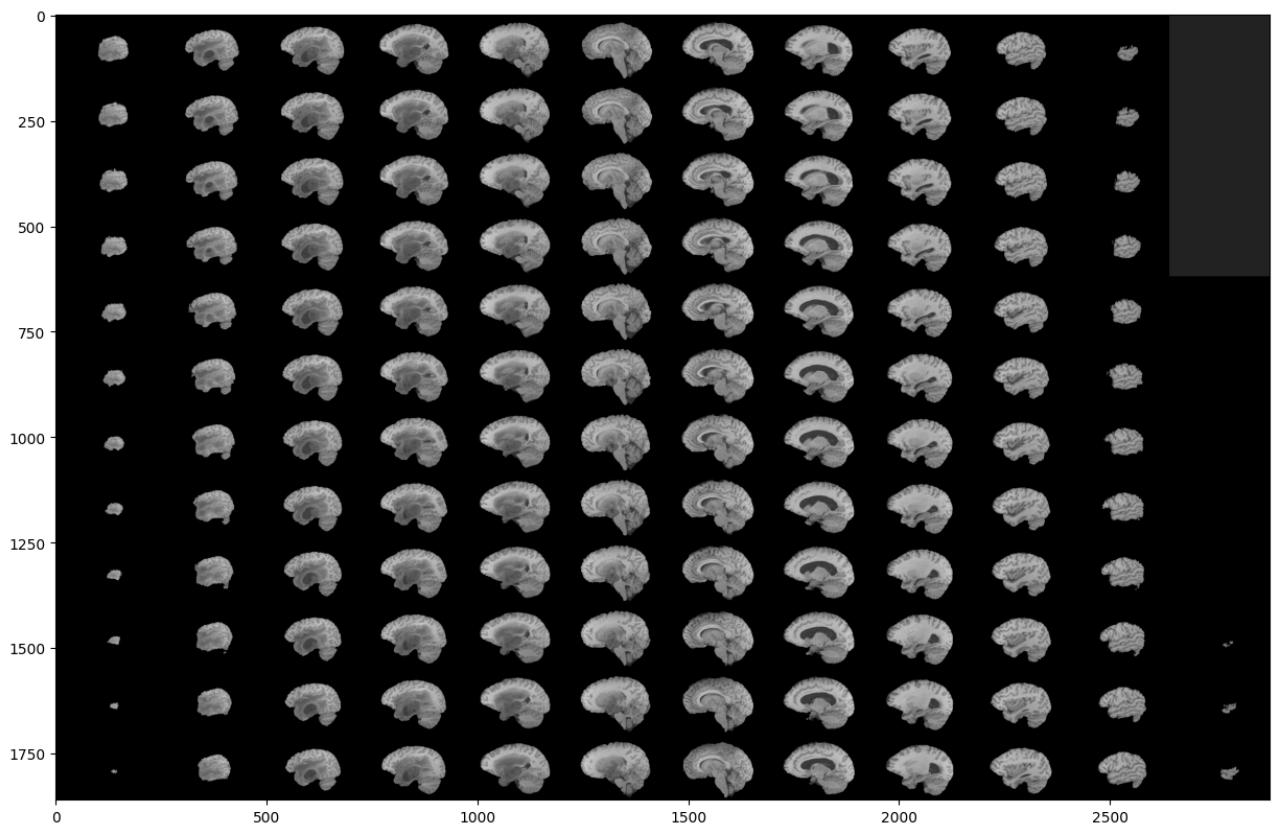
Images of cross-sectional views of the 3-D MRI Scan of the brain from BraTS dataset.
